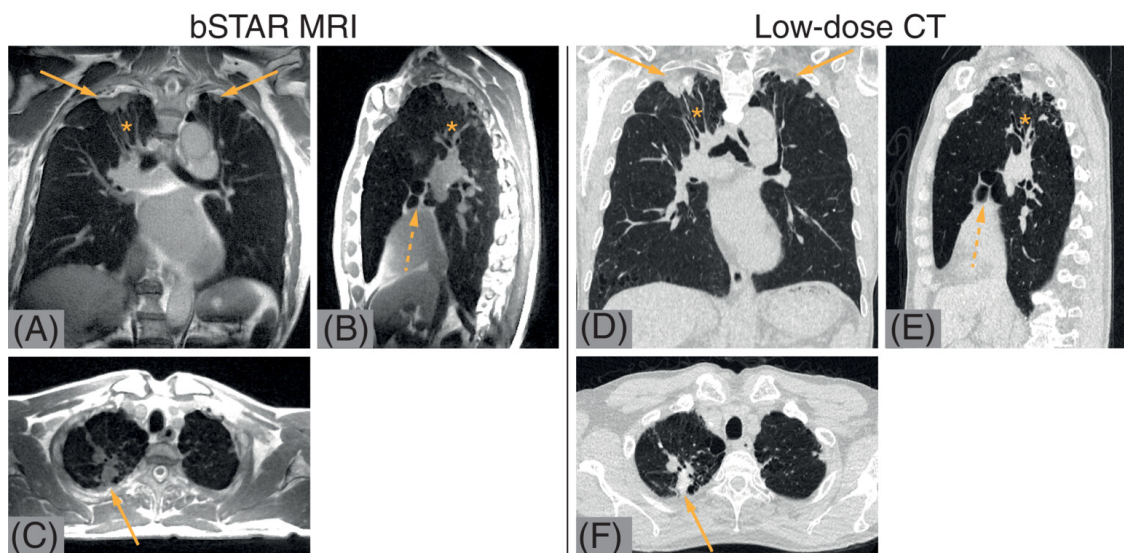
bSTAR MRI (left) and CT (right) 3D images in the lung of a 74-year-old patient with granulomatous lung disease.⁶² The bSTAR sequence is derived from balanced steady-state free precession (bSSFP) sequences with the addition of a second echo. Contrasts differ, but the excellent signal-to-noise ratio (SNR) obtained with the bSTAR sequence enables distal vessels to be imaged with a submillimetric resolution (0.9 mm isotropic resolution in a 12:50 min acquisition).
